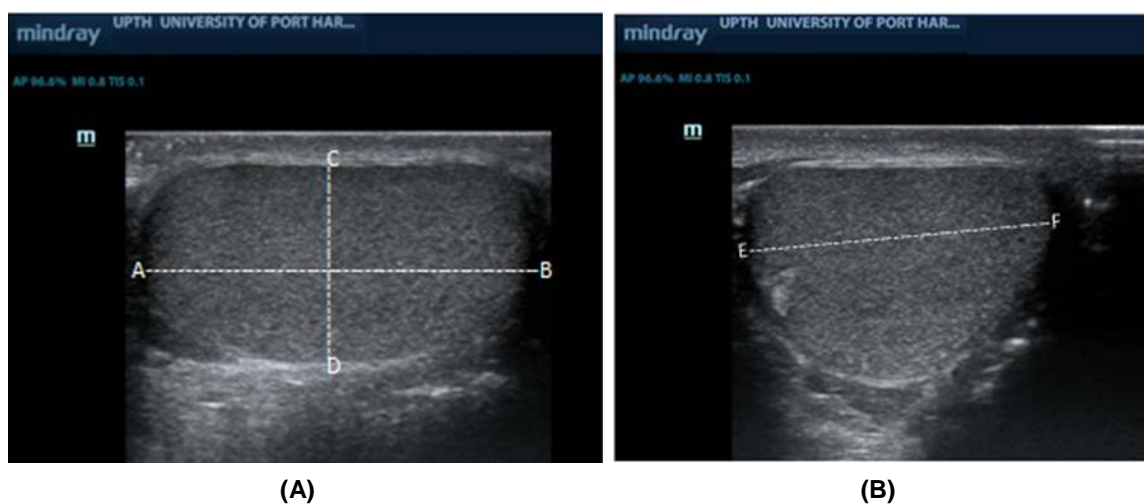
Grey scale ultrasound of a normal testis showing points of measurement: (A) longitudinal image; (B) transverse image
